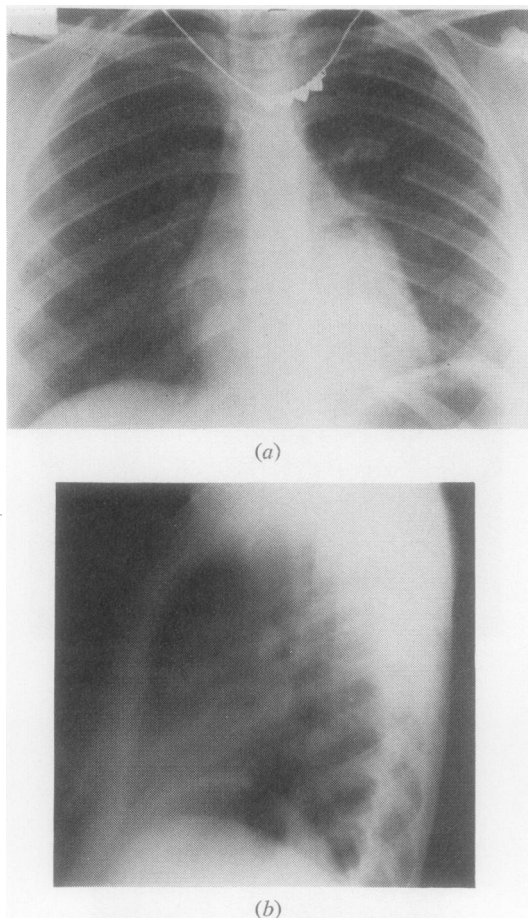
Chest radiograph in P-A (a) and lateral (b) positions after removal of the tumour.
